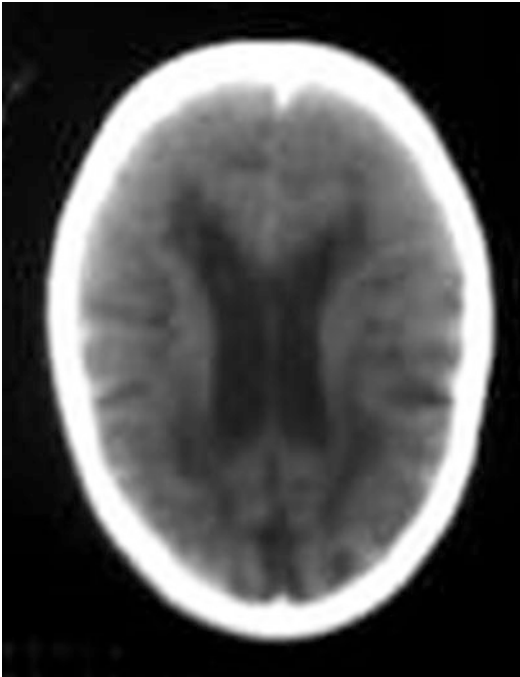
CT scan of the head of a patient showing ventriculomegaly with congenital hydrocephalus
